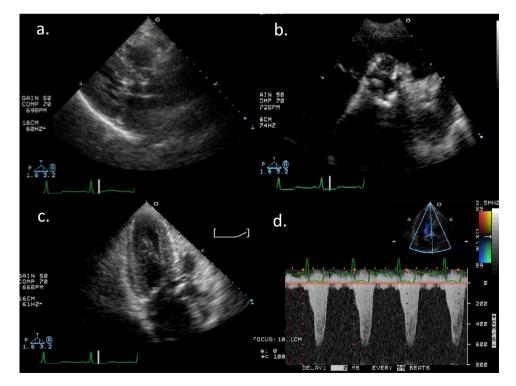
The transthoracic echocardiograms. (a) The transthoracic echocardiogram in the parasternal long-axis view during the mid-systolic period reveals asymmetric septal hypertrophy, systolic anterior motion (SAM) of the mitral valve, and a left ventricular outflow tract (LVOT) obstruction. (b) The short-axis view of the aortic valve reveals a calcification of the noncoronary cusp. (c) This three-chamber view also shows SAM and an LVOT obstruction. There were calcific changes in the aortic valve. (d) Continuous-wave Doppler echocardiography revealed that the pressure gradient was 159 mmHg (6.3 m/s) at rest.
